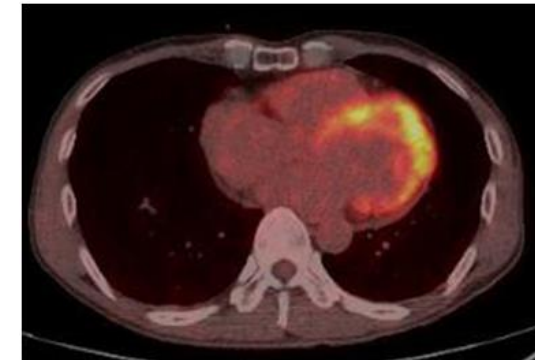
FDG-PET showing the focal on diffuse uptake pattern, which can support the diagnosis of cardiac sarcoidosis.
